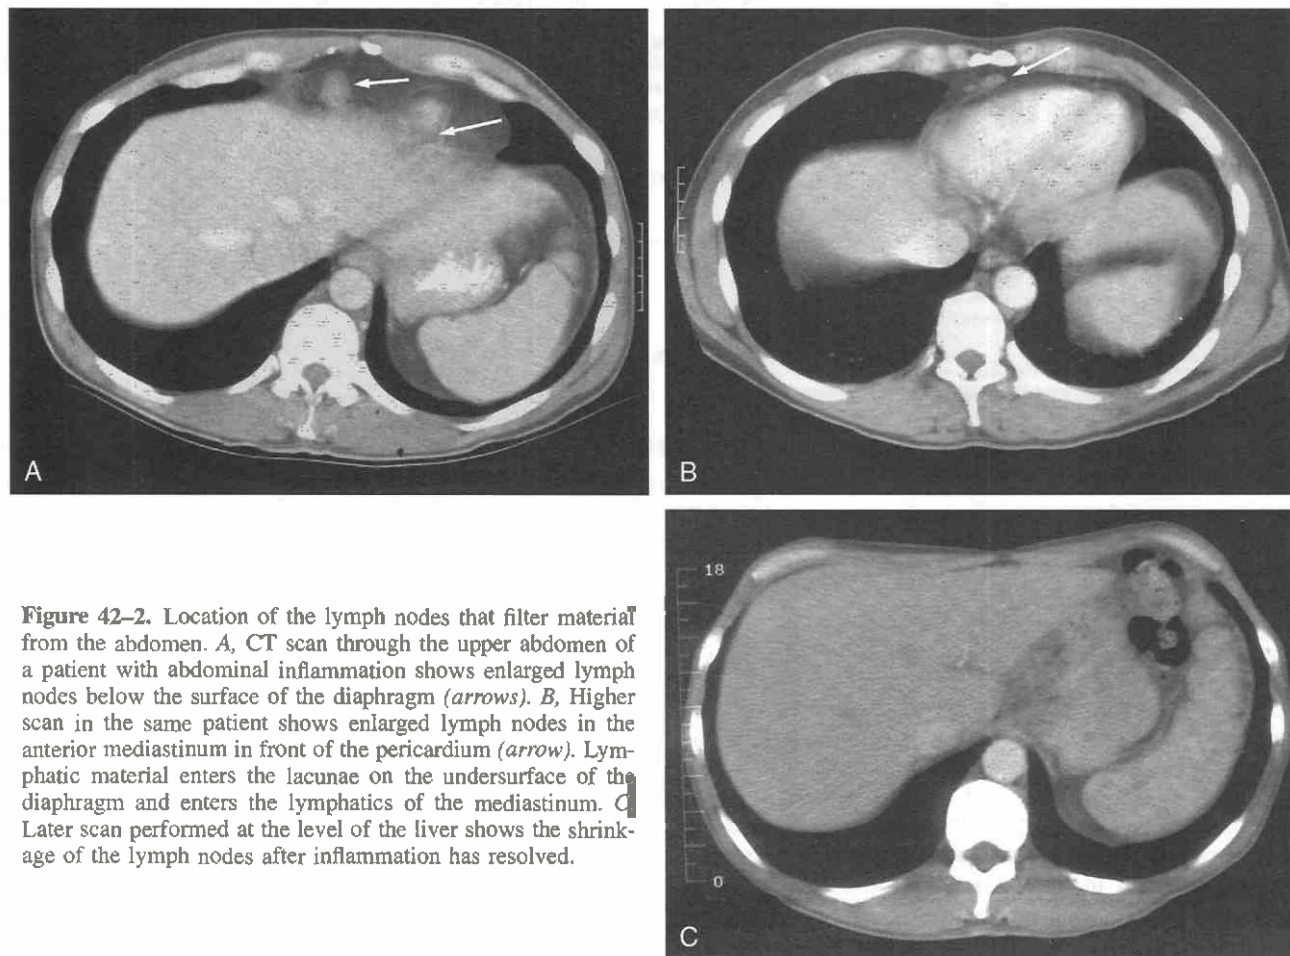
Location of the lymph nodes that filter material from the abdomen. A, CT scan through the upper abdomen of a patient with abdominal inflammation shows enlarged lymph nodes below the surface of the diaphragm (arrows). B, Higher scan in the same patient shows enlarged lymph nodes in the anterior mediastinum in front of the pericardium (arrow). Lymphatic material enters the lacunae on the undersurface of the diaphragm and enters the lymphatics of the mediastinum. C, Later scan performed at the level of the liver shows the shrinkage of the lymph nodes after inflammation has resolved.
